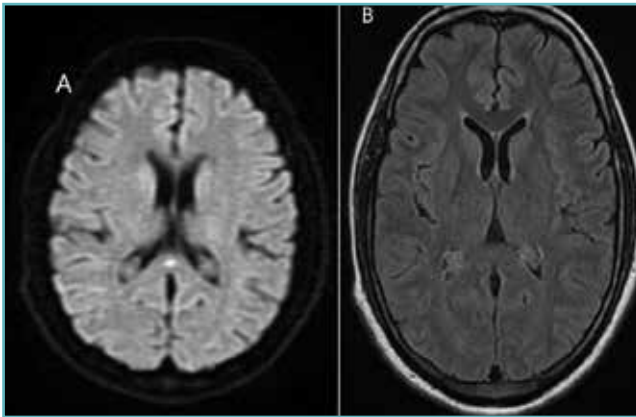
Magnetic resonance imaging (MRI) findings showing cytotoxic lesions in the splenium of the corpus callosum, characterised by restricted diffusion and hyperintensity on T2-FLAIR images.
